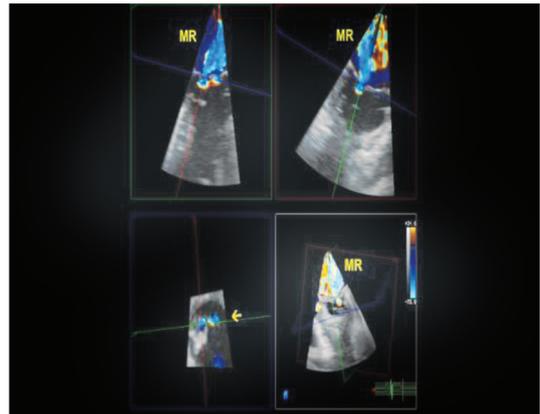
Measurement of vena contracta dimensions from a three-dimensional transesophageal echocardiogram color Doppler data set using three-dimensional analysis software. Note the asymmetric shape of regurgitant orifice.
